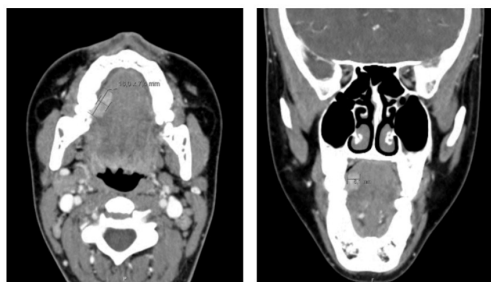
Axial contrast-enhanced CT showing a well-circumscribed, enhancing, oblong lesion (18 × 8 mm) in the right lateral tongue, without deep extension or lymphadenopathy.
